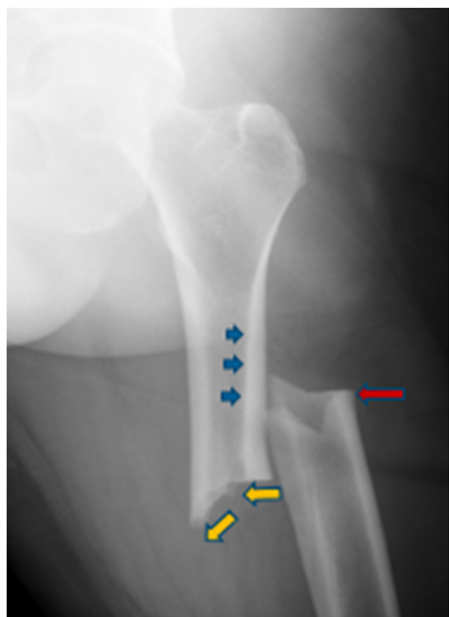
Preoperative radiograph. Atypical femur fracture showing transverse fracture line with medial obliquity (yellow arrows), flaring at the lateral cortex at the fracture site (pink arrow), thickening of the diaphysis of the lateral cortex (blue arrows).
